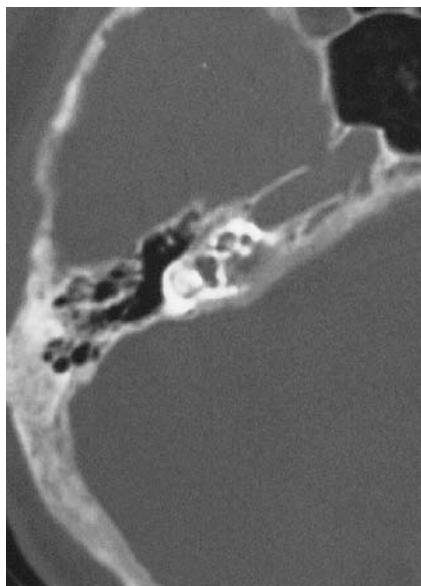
Paget's disease of the temporal bone. Axial bone-window CT demonstrates abnormal lucency throughout the temporal bone, with relative sparing of the otic capsule
